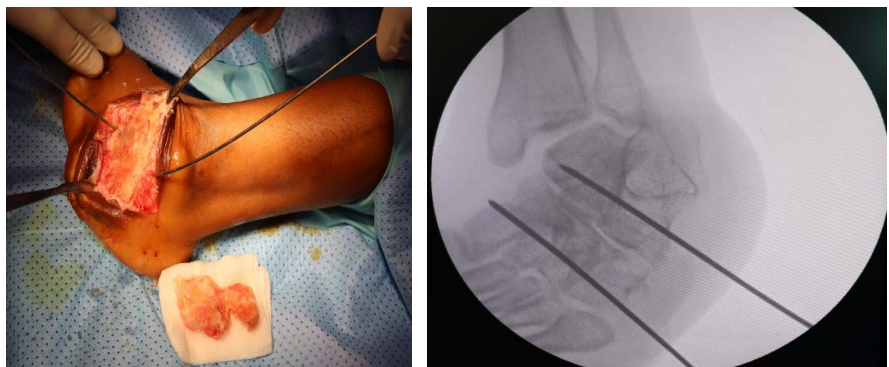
Shows an intraoperative clinical photo and X-ray.
